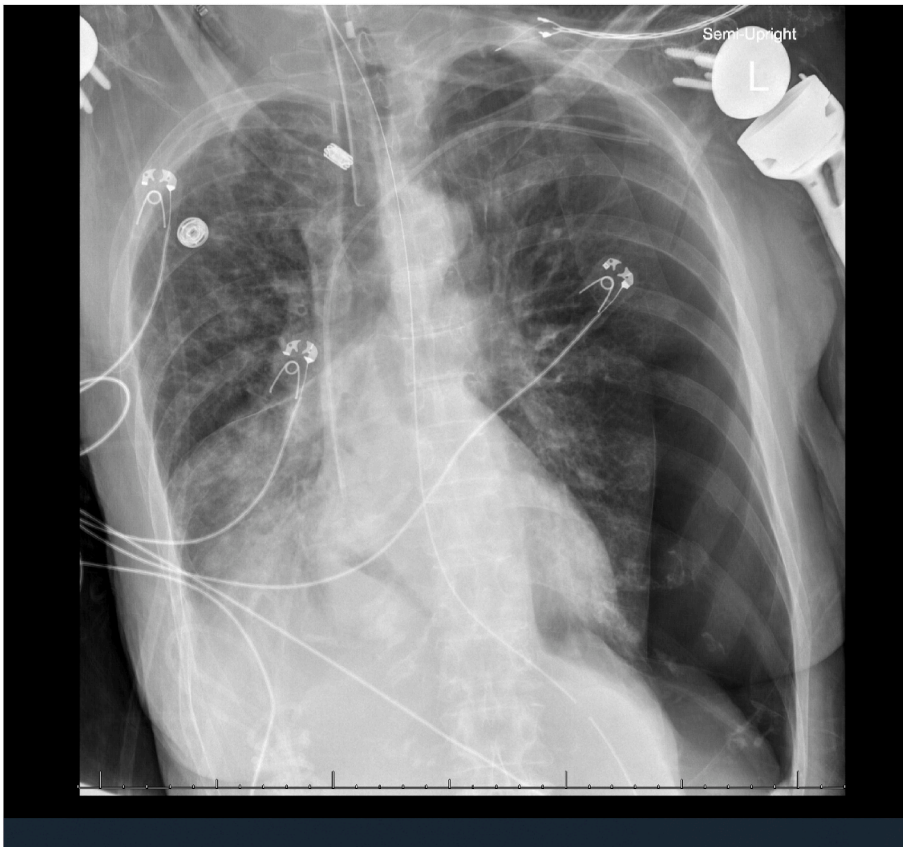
Day 3 chest x-ray.
